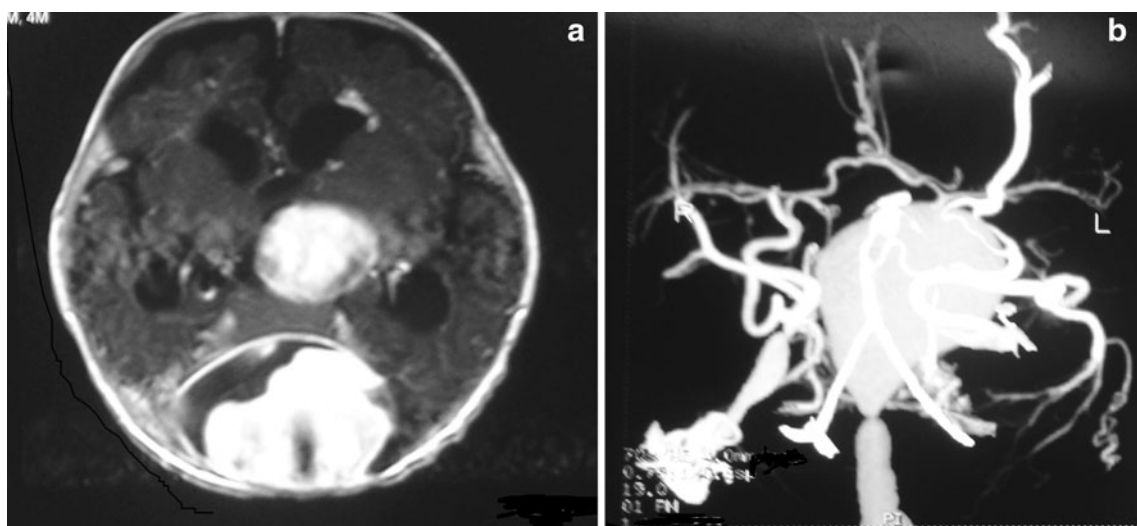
Brain magnetic resonance imaging (a) and magnetic resonance angiography (b) confirms vein of Galen aneurysmal malformation accompanied by thrombosis formation and dilated torcula
